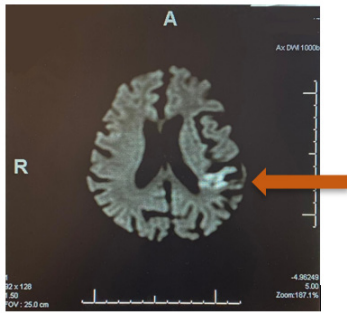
MRI brain image (DWI sequence): An acute infarction in the left parietal lobe (Arrow) with an underlying hemorrhagic component.
